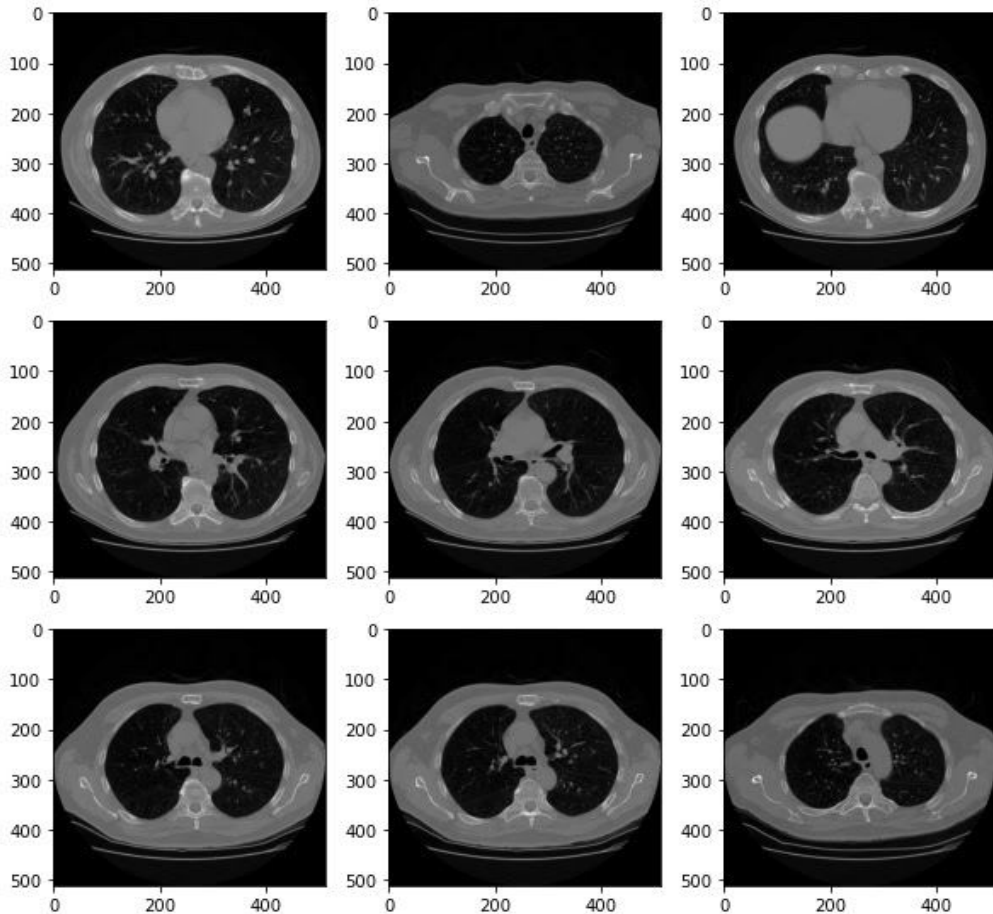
Primary CT scan DICOM slices extraction from LUNA16 dataset
